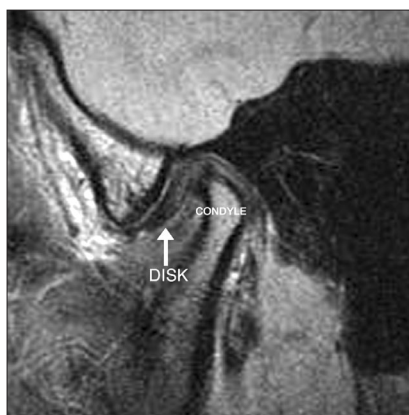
Magnetic resonance imaging of the mouth in the closed position showing the articular disc displaced anteriorly.
